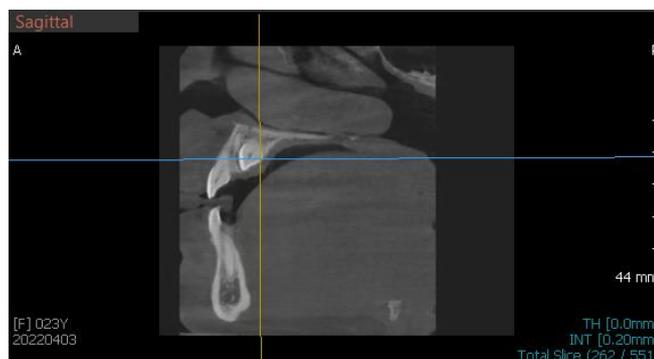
Patient's CBCT. Sagittal section.
